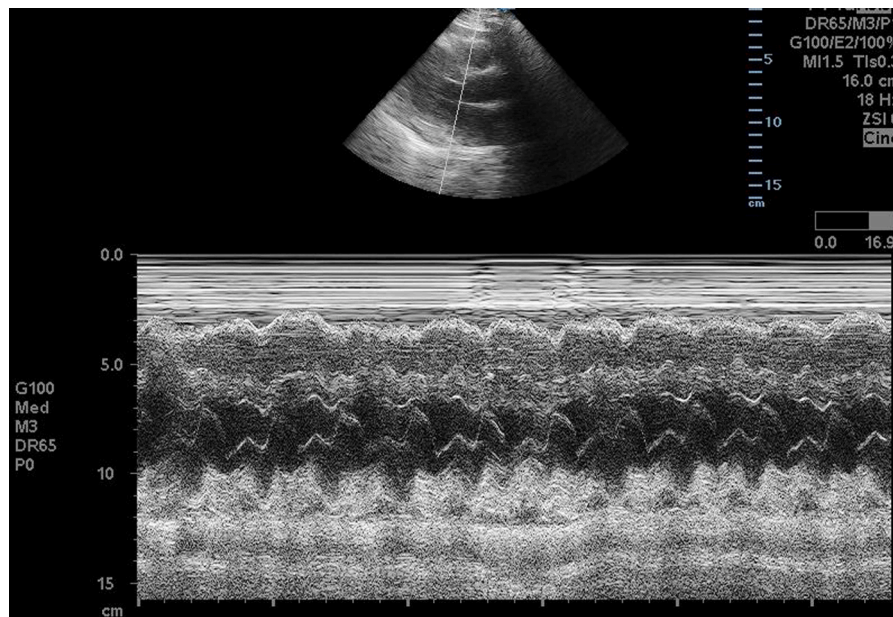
POCUS Echocardiogram parasternal long axis showing pericardial effusion with M mode that demonstrated mild RV collapse during diastole.
